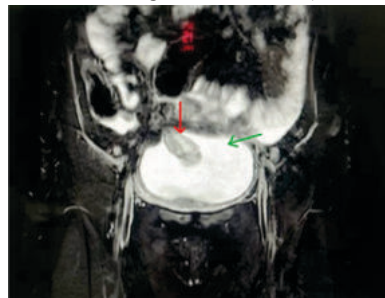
MRI pelvis showing an intravesical mass attached to right lateral wall of bladder (Red arrow- mass attached to bladder wall, Green arrow- urinary bladder)
